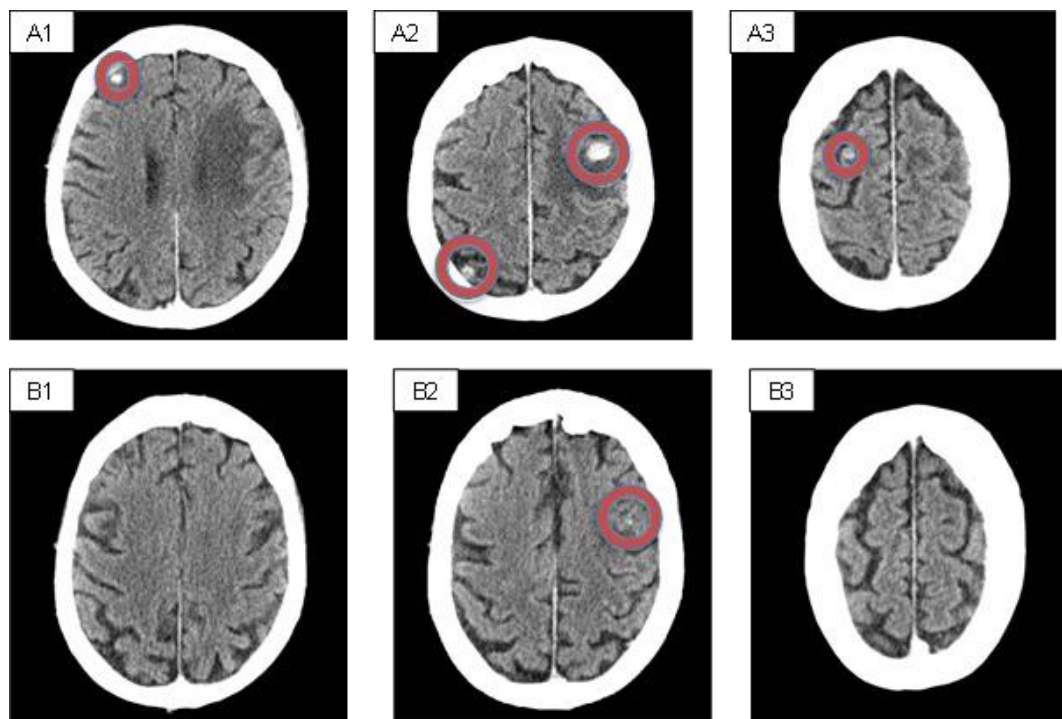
CT images of the brain before (June 2024, A) and two months after (August 2024, B) starting treatment with capmatinib. A1 shows the small right frontal lesion, A2 shows the largest lesion which was located in the left frontal lobe (largest diameter, 12.61 mm), and A3 a small right parietal lesion. B1 and B3 show no lesions and B2 shows the left frontal lesion greatly decreased in size (largest diameter, 7 mm).
